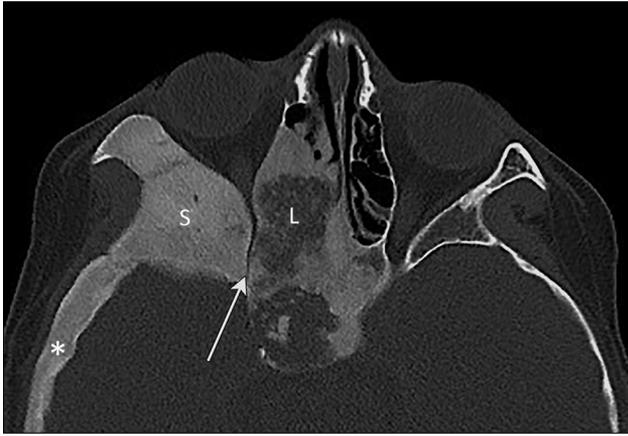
Axial computed tomography (CT) scan of 11-year-old male patient with fibrous dysplasia (FD). The arrow indicates the optic canal that is significantly narrowed. Asterisk highlights the blending of affected bone with surrounding bone, a feature characteristic of FD. The bony CT findings with FD can include both sclerotic (S) and lytic (L) areas. Image courtesy of Jeffrey Rastatter, MD.
